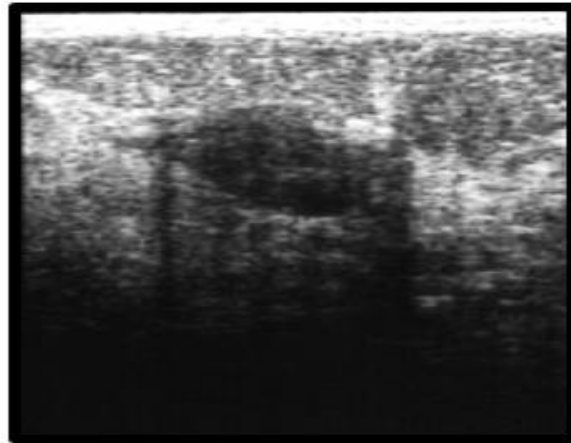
Breast ultrasound. Presence of an oval-shaped mass, with circumscribed contours, homogeneous, with posterior attenuation
